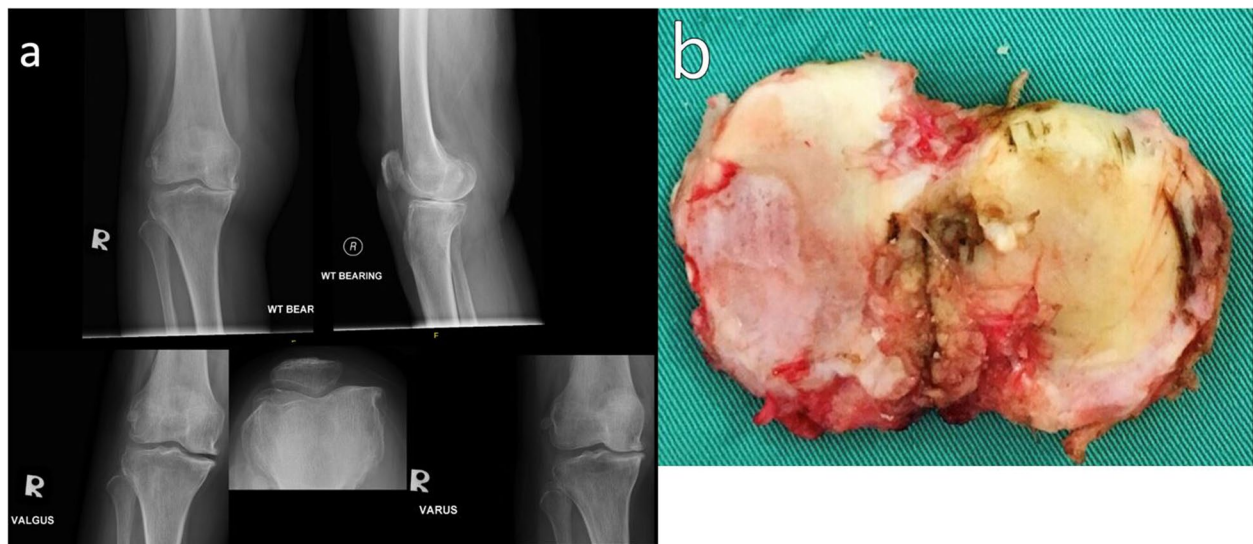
a Radiographs assessed using the Oxford Radiological Decision Aid (ORDA). (b) The tibial “biscuit” was assessed for lateral compartment wear and photographed for evaluation
